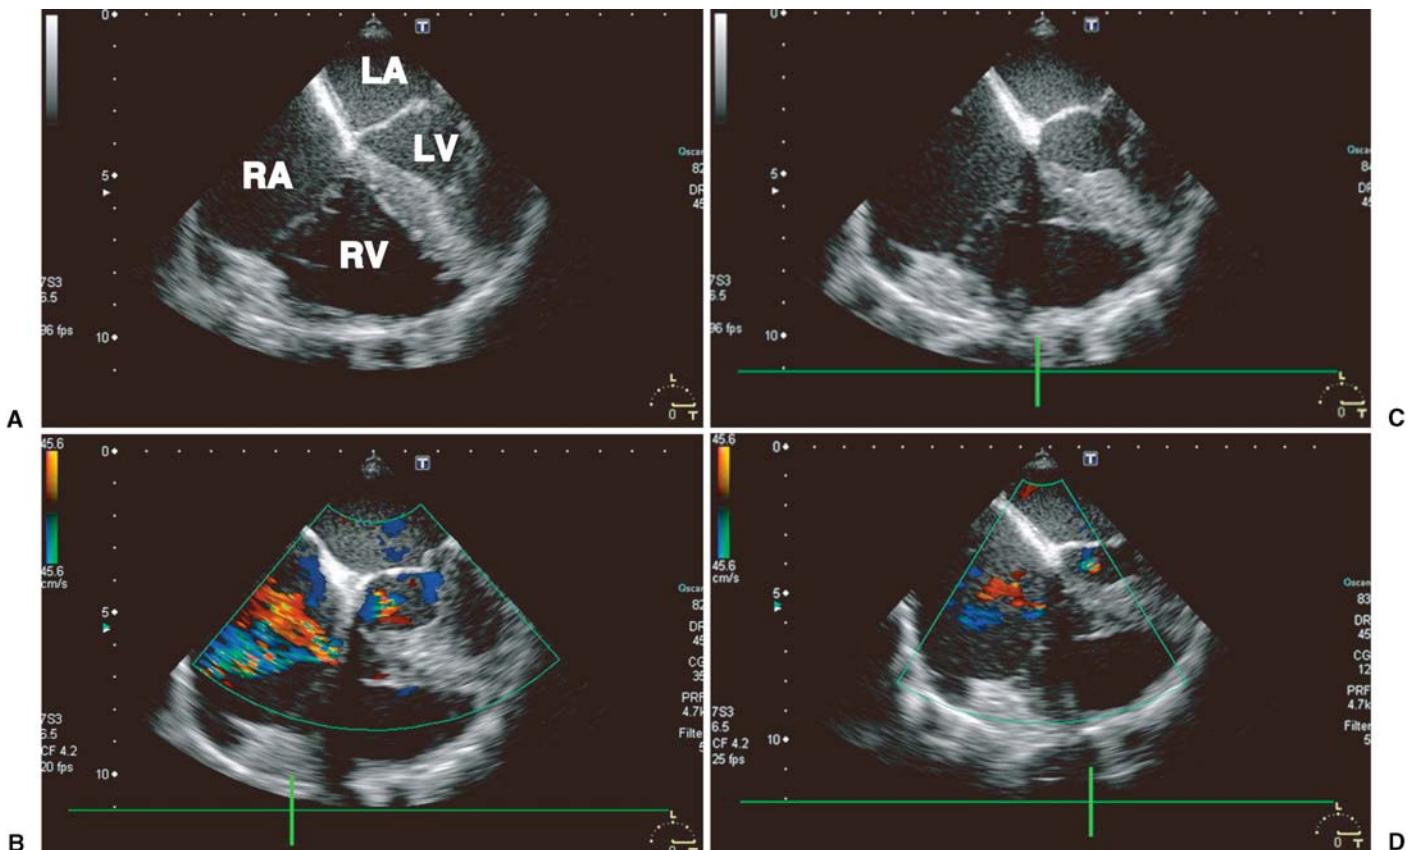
Four-chamber view of transesophageal echocardiography (TEE) imaging performed before (A, B) and after (C, D) aortocaval fistula repair. After the induction of anesthesia, TEE showed enlarged right atrium (*RA*) and right ventricle (*RV*; A) and color Doppler showed massive tricuspid
